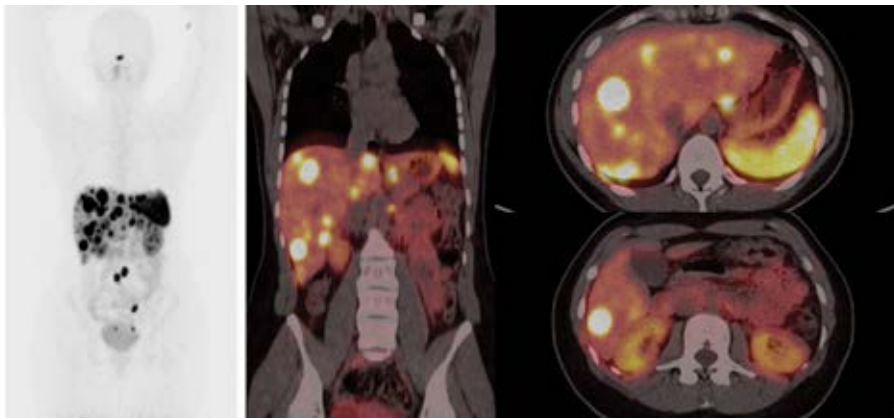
^{68}Ga DOTATATE PET/CT showed multiple liver metastasis and paraaortic lymph node, which in part correspond with $^{99\text{m}}\text{Tc}$ -HYNICTOC examination. On MIP (maximal image projection) additional foci in the intestine and pelvis was shown
